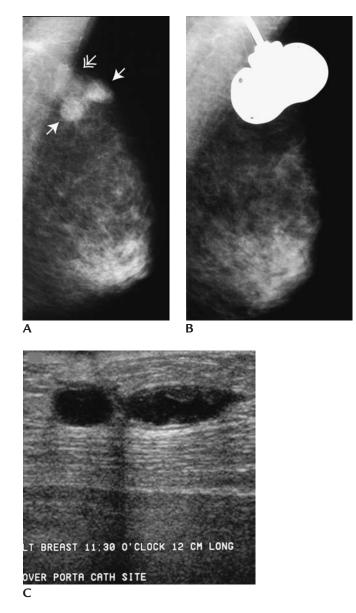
Portable catheter (port-a-cath) site changes. (A, B) Left mediolateral oblique views, 1 year apart. Two adjacent masses (*arrows*) and an irregular area of increased density (*double headed arrow*) are seen at the prior port-a-cath site. (C) Two adjacent fluid collections are identified on ultrasound corresponding to the mammographic findings. No further intervention is required. Complete resolution is noted a year following (A).
